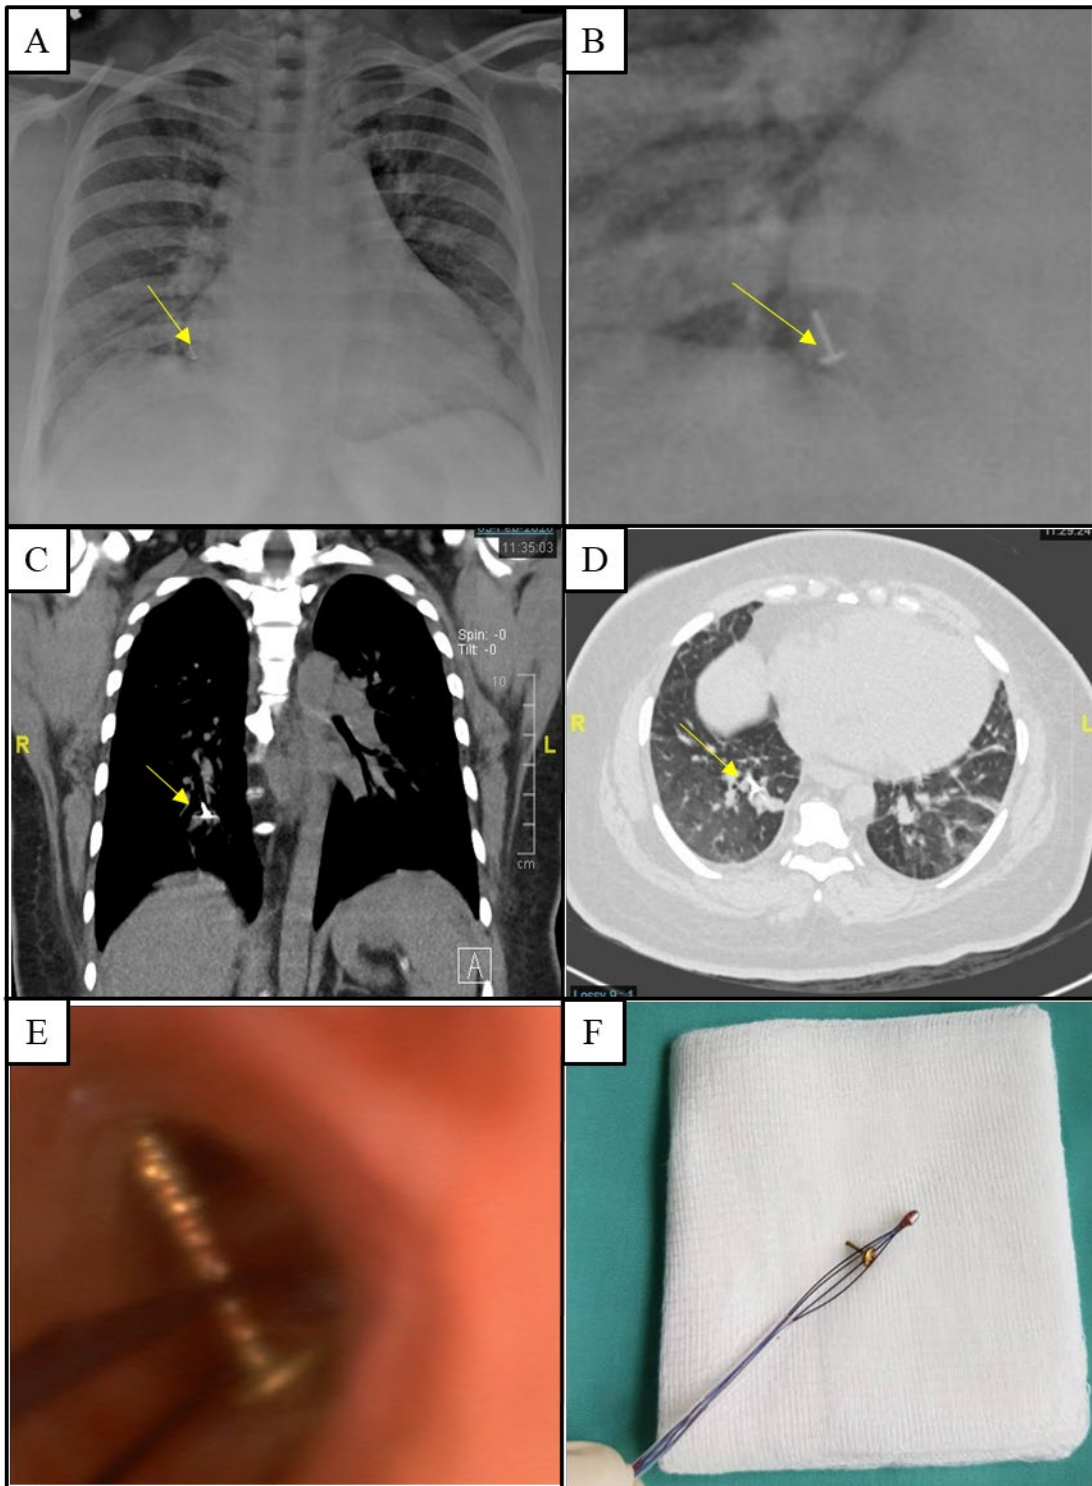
Chest radiograph, Computer tomography, bronchoscopy image, and image of the foreign body. (A) Chest radiograph showing small radio-opaque foreign body in the right lower lobe (yellow arrow). (B) Magnified image of the foreign body in the chest radiograph (yellow arrow). (C) Contrasted computed tomography of thorax (mediastinal window) in coronal view revealed a screw shaped foreign body in the posterior basal segment (RB10) of right lower lobe (yellow arrow). (D) Contrasted computed tomography of thorax (lung window) in axial view showing the foreign body located at posterior basal segment (RB10) of right lower lobe with segmental collapse (yellow arrow). (E) Foreign body embedded into bronchial mucosa, surrounded by granulation tissue. (F) Successful retrieval of screw of nose stud using retrieval basket.
